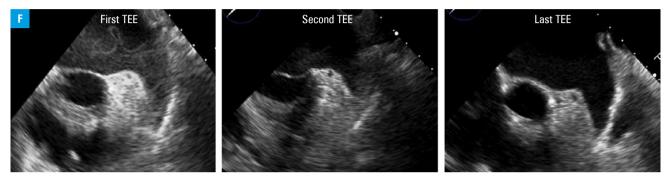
Associations between atrial fibrillation (AF)-related cytokines and left atrial spontaneous echo contrast in patients with nonvalvular AF; D – serum IL-17A levels at the time of baseline and follow-up transesophageal echocardiography (TEE) in 17 patients who underwent TEE  $\geq$ 2 times; E – serum IL-17A levels of a 69-year-old woman at the time of baseline and 2 follow-up TEEs; F – ultrasound images of the 3 TEEs performed in the abovementioned woman
